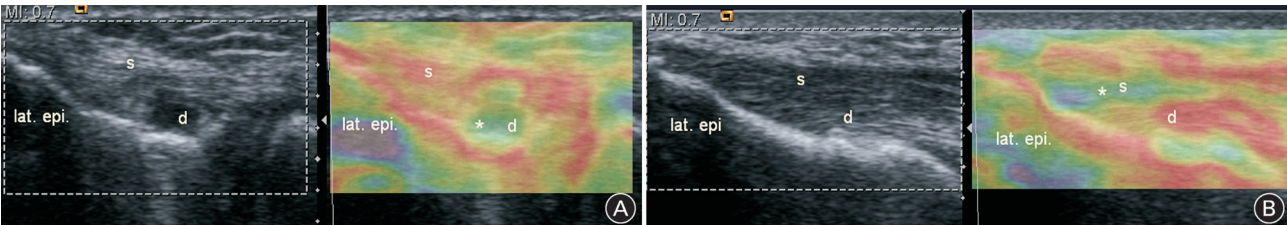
Longitudinal ultrasonographic and sonoelastographic findings of lateral elbow tendinopathy in the superficial (A) and deep (B) layers of the common extensor tendon. The stars represent areas of tendinopathy with sonoelastographic Score 1 or 2. lat. epi.=lateral epicondyle; s=superficial layer; d=deep layer.
